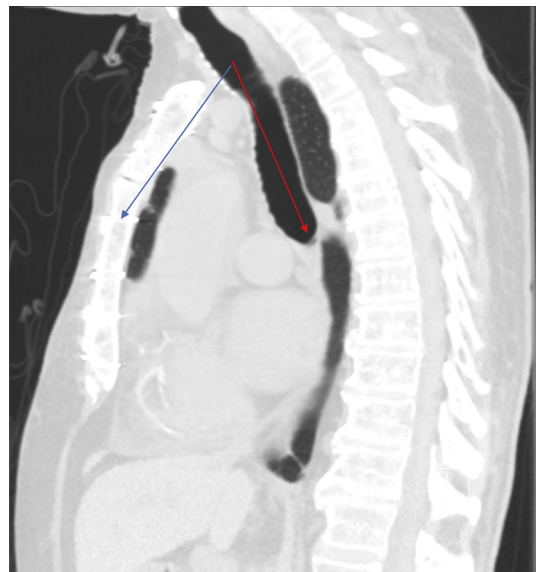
Coronal CT images of an 82-year-old man. Note that the angle between the trachea (*red arrow*) and the sternum (*blue arrow*) is more pronounced than the younger patient in Fig. 1.
